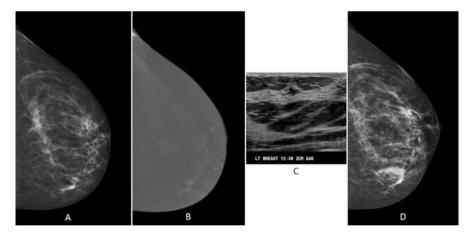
Thirty-nine-year-old woman with indeterminate calcifications in the medial left breast on screening mammogram. (a) Craniocaudal (CC) view of left breast mammogram demonstrates pleomorphic calcifications in the medial left breast. (b) Recombined CC view from contrast-enhanced mammogram (CEM) confirms the suspicious medial calcifications with associated irregular non-mass enhancement. In addition, there is 7-mm-enhancing mass in the anterior lateral left breast. (c) Suspicious hypoechoic left breast mass with irregular margins identified on subsequent diagnostic ultrasound, corresponding to mass only identified on CEM. (d) Post-biopsy CC mammogram confirms appropriate clip placement in expected location of left breast mass and left breast calcifications, which were confirmed as grade 1 invasive ductal carcinoma and grade 3 DCIS, respectively
